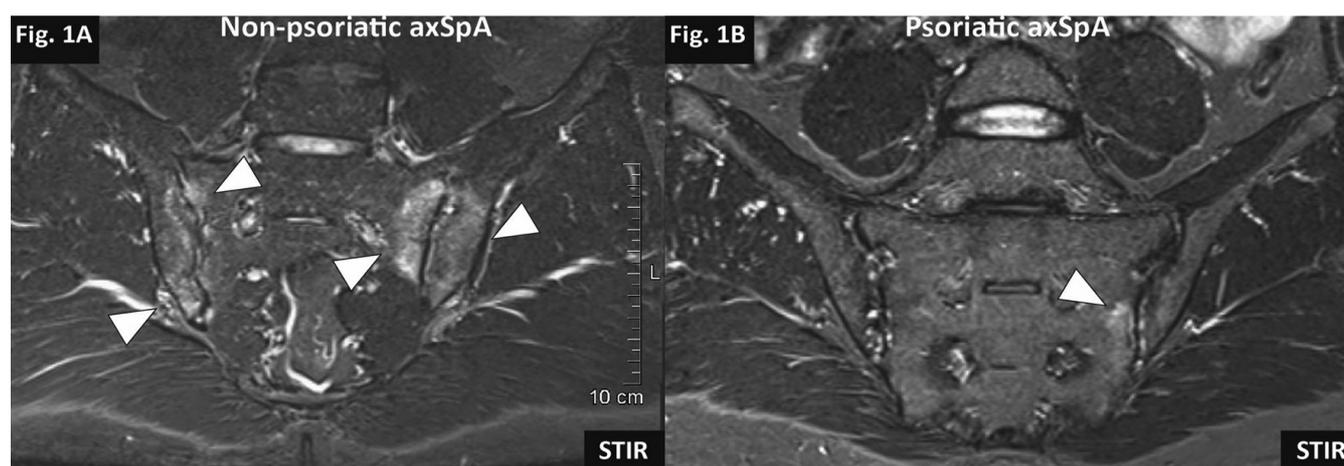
MRI evidence of bilateral and unilateral SIJ bone marrow oedema in patients with non-psoriatic and psoriatic axSpA (images courtesy of X. Baraliakos) Typically, bone marrow oedema (arrowheads) appears bilaterally and with larger extent in patients with non-psoriatic axSpA, and unilaterally with less extent in patients with psoriatic axSpA. axSpA: axial spondyloarthritis; MRI: magnetic resonance imaging; STIR: short tau inversion recovery.
